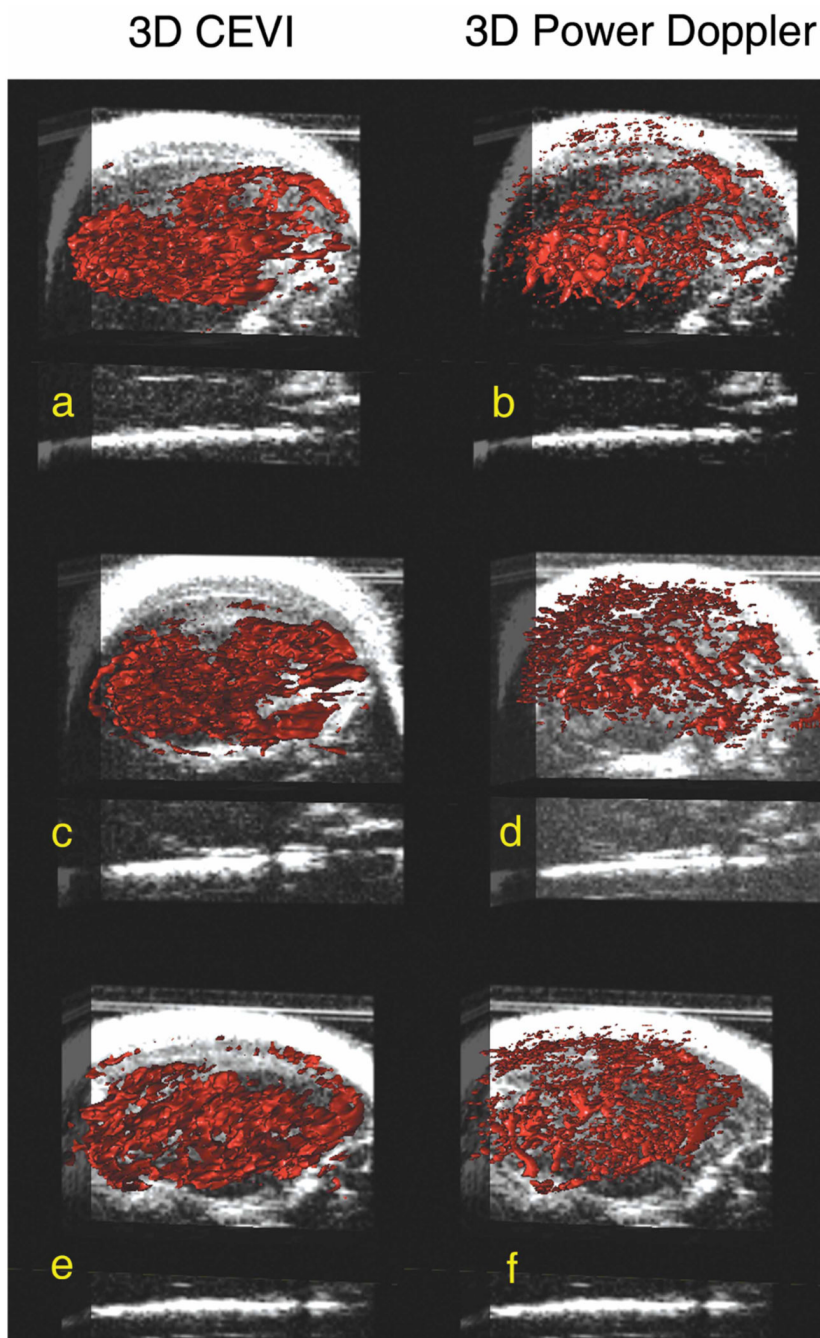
Three-dimensional surface renderings of both the reconstructed 3D contrast-enhanced images (a, c and e) and 3D power Doppler images (b, d, and f) overlaid on slice-by-slice anatomic B-mode data. By applying the technique summarized in Figure 3 to all images in the tumor volume, the aligned images produced a 3D rendering of the sections of tissue, which showed significant enhancement due to the presence of intravascular microbubbles shown in a, c, and e.
